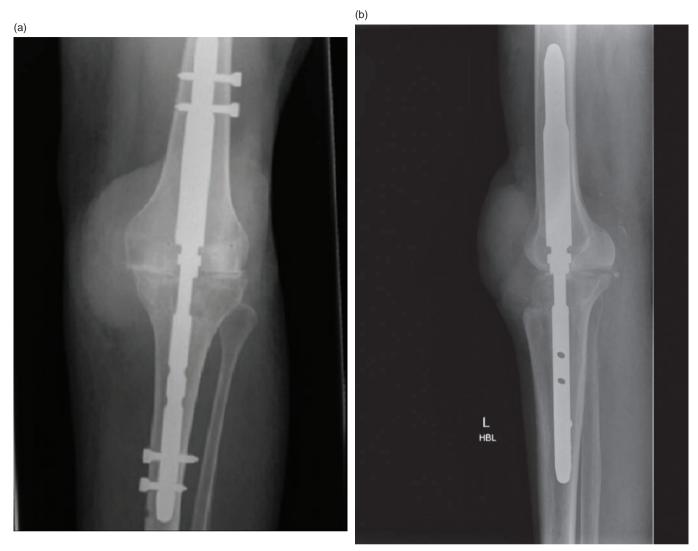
Knee arthrodesis (a, b: AP and lateral radiographs) secondary to loss of extensor mechanism following a severe 3% full thickness burn over her knee joint with concurrent infection and partial neuropathy in a diabetic 79-year-old woman. This was done using a Whichita Fusion Nail[®] and the patient achieved full union with very good function and resumed independence⁷⁷
